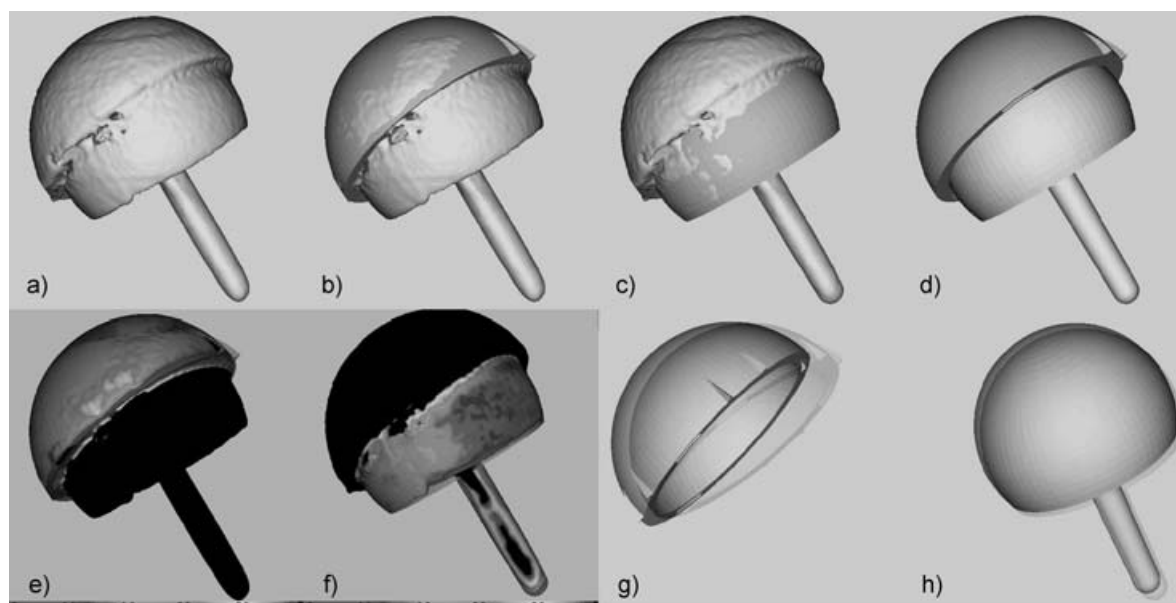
CT-based comparison of planned versus achieved position for a navigated femoral component and conventionally implanted (non-navigated) acetabular component
